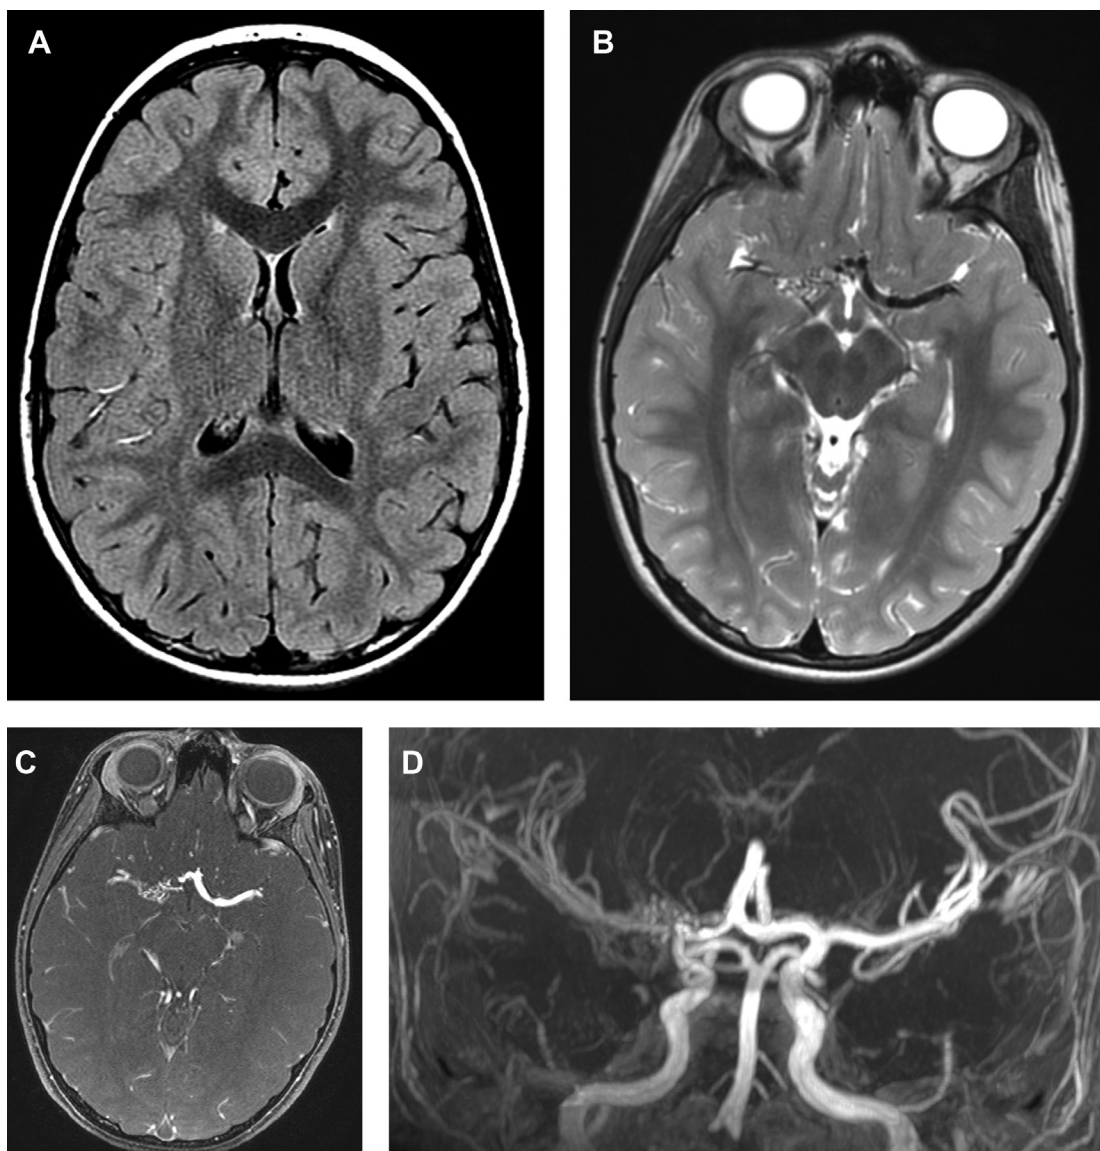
A 9-year-old girl with headaches and right-sided moyamoya vasculopathy. (A) Axial FLAIR MR imaging demonstrates ivy sign connoting leptomeningeal collateral flow in the right cerebral hemisphere. Axial T2-weighted image (B), axial time-of-flight MR arteriography image (C), and coronal time-of-flight MR arteriography maximum intensity projection 3-D reconstruction (D) demonstrate severe narrowing of the right internal carotid artery terminus and the A1 and M1 segments, with numerous middle cerebral artery (MCA) cistern collaterals and pruning of distal MCA branches. The patient was treated with pial synangiosis.
